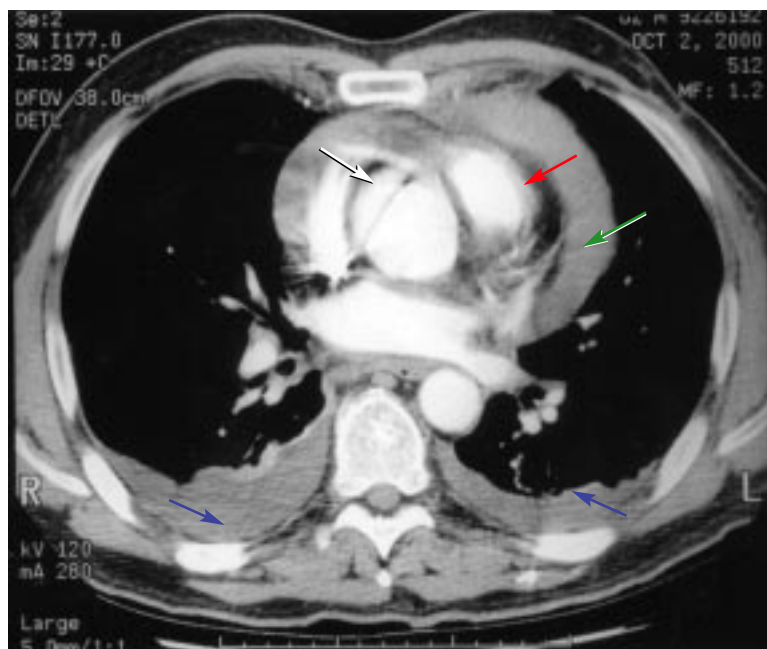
Chest CT demonstrates a large aneurysmal ascending aorta with luminal filling defect characteristic of a type 1 aortic dissection (white arrow). Cardiomegaly (red arrow) and a large pericardial effusion (green arrow) are also noted. There was no evidence of dissection along the transverse or descending aorta. There was bilateral atelectasis (right more than left) (blue arrows) but no mediastinal or hilar lymphadenopathy.
